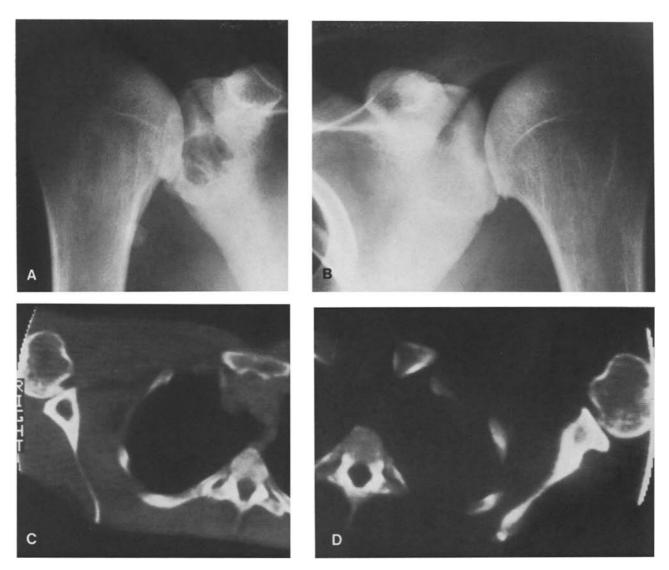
D (Case 1). A Anteroposterior view (AP) of the right shoulder; glenohumeral joint space narrowing is present with an osteophyte noted on the humerus. A large subchondral cyst is present in the glenoid. A loose body is also noted. B AP view of left shoulder; an osteophyte is noted on the humeral head adjacent to the inferior glenoid. Subchondral sclerosis is present throughout the glenoid. These findings are consistent with DJD. C CT scan through the right shoulder: a large subchondral cyst seen on the plain film in the glenoid is demonstrated. An osteophyte and subchondral sclerosis are seen in the humerus. D CT scan of the left shoulder: subchondral sclerosis and spurring are seen on the glenoid. Minimal subchondral sclerosis and spurring are also seen in the humeral head
